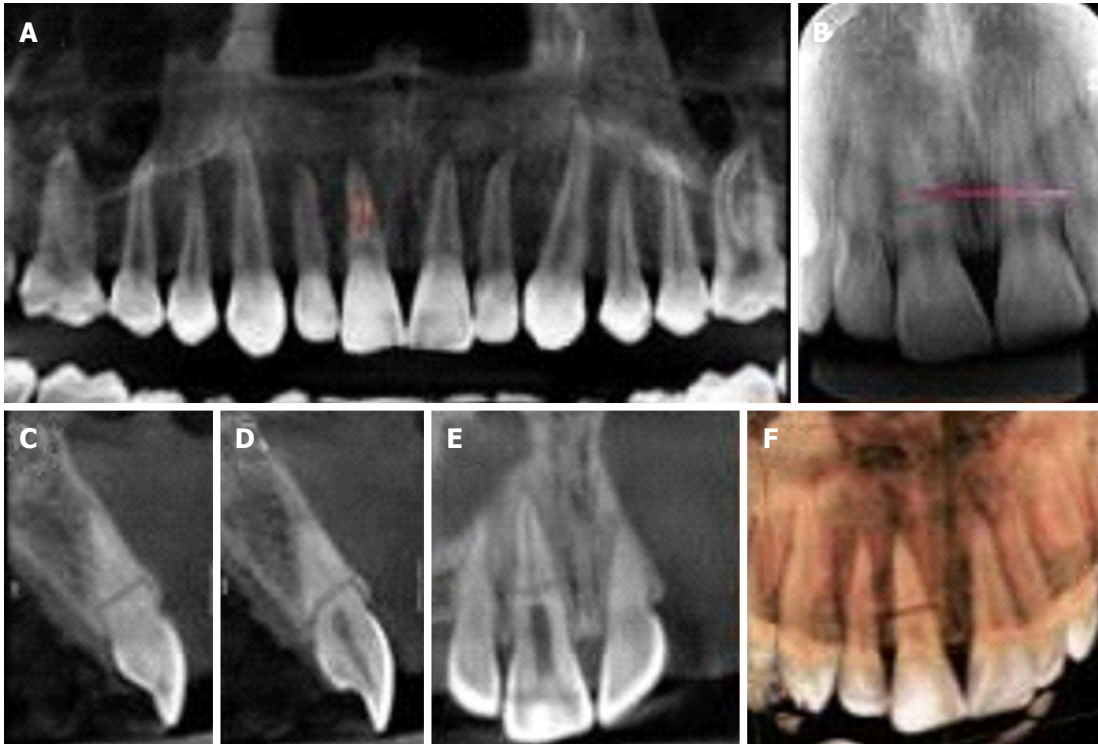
Cone beam tomography. A: Panoramic coronal reconstruction of the maxilla; B: Periapical Radiograph, showing horizontal root fracture in the middle third of tooth 11; C and D: Sagittal reconstructions of tooth 11, from mesial to distal sequence; E: Coronal reconstructions of the upper incisors, from buccal to lingual direction; F: 3D reconstructions (buccal and lingual views).
